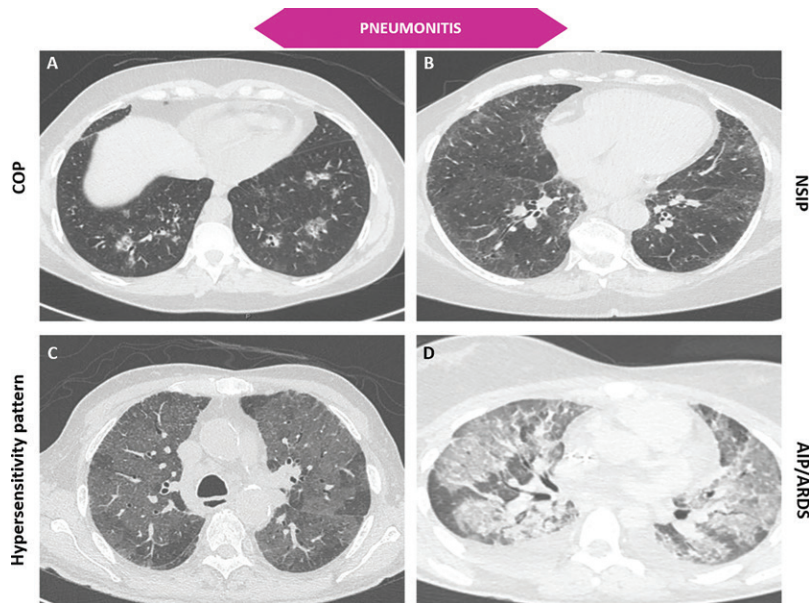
Axial CT images of the four most common patterns of immunotherapy-induced pneumonitis. *A*, Cryptogenic organizing pneumonia (COP) involves multifocal regions of consolidation and ground-glass opacities (GGOs) with a peripheral and basilar distribution. *B*, Nonspecific interstitial pneumonia (NSIP) involves GGOs and reticular opacities with a subpleural distribution. *C*, Hypersensitivity pneumonitis involves multifocal GGOs with a centrilobular distribution and mosaic attenuation. *D*, Acute interstitial pneumonia/acute respiratory distress syndrome (AIP/ARDS) involves diffuse GGOs and traction bronchiectasis.
